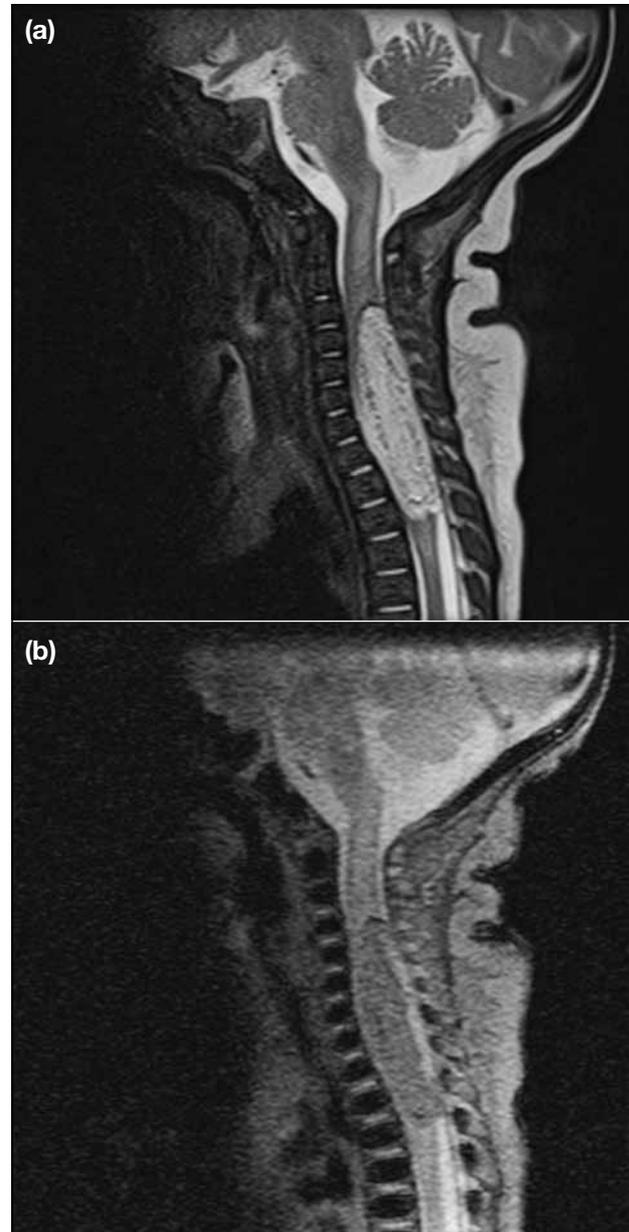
(a) Comparing T2-weighted sagittal magnetic resonance image and (b) fat saturation images showing that the hyperintense signal of the mass was suppressed on fat-saturation images, indicating lipomatous nature.
